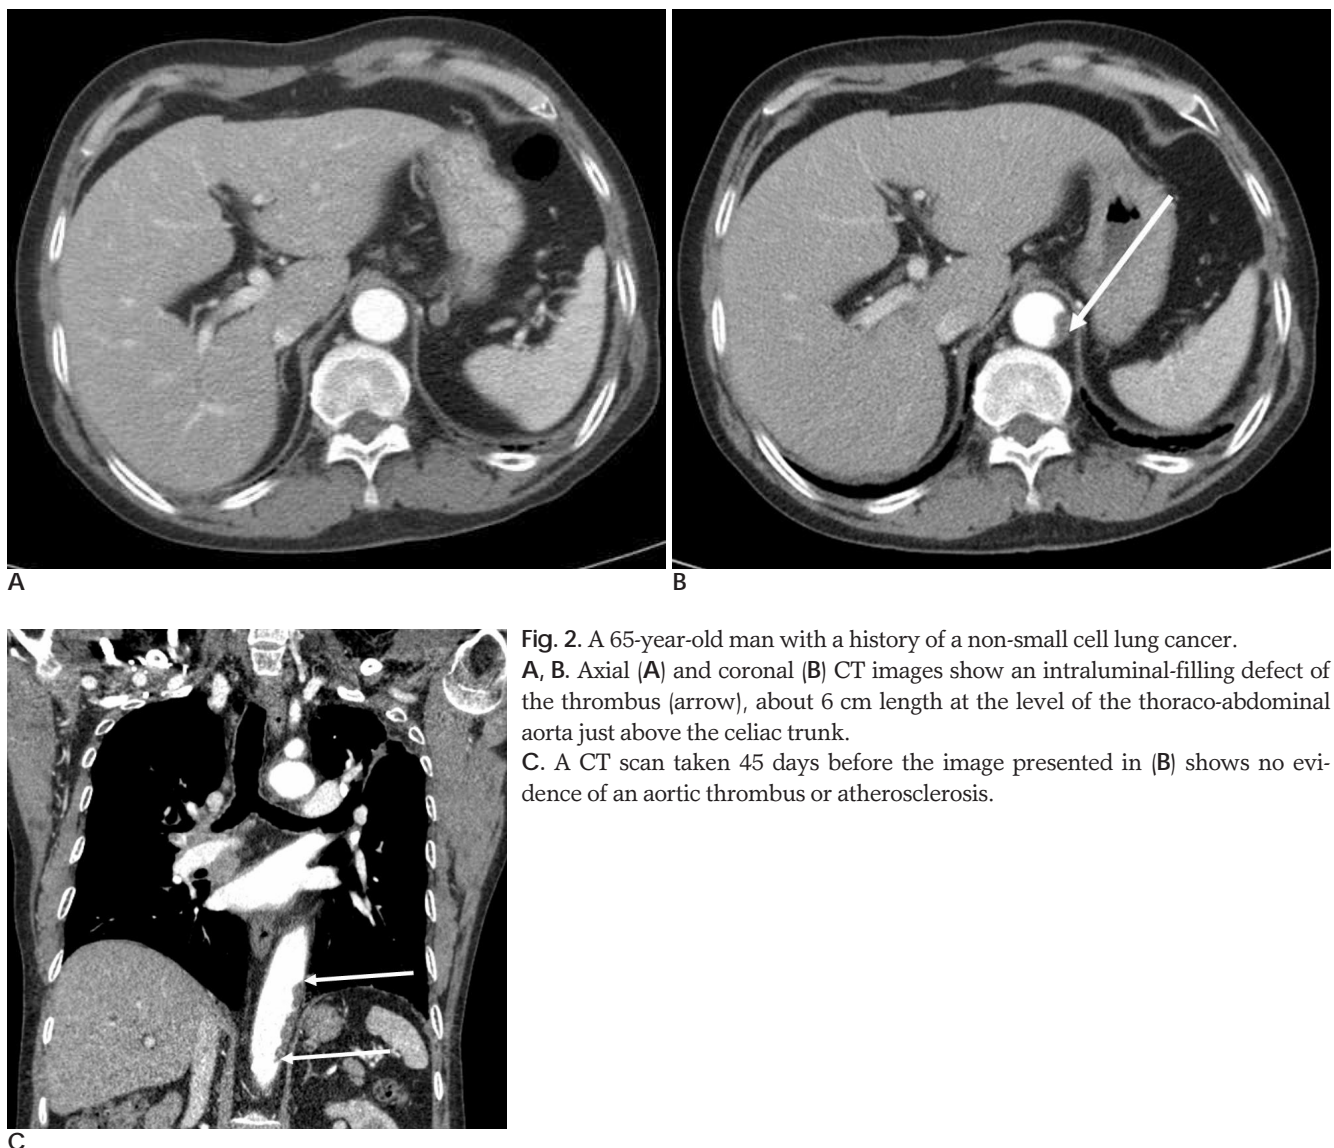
A 65-year-old man with a history of a non-small cell lung cancer. A, B. Axial (A) and coronal (B) CT images show an intraluminal-filling defect of the thrombus (arrow), about 6 cm length at the level of the thoraco-abdominal aorta just above the celiac trunk. C. A CT scan taken 45 days before the image presented in (B) shows no evidence of an aortic thrombus or atherosclerosis.
